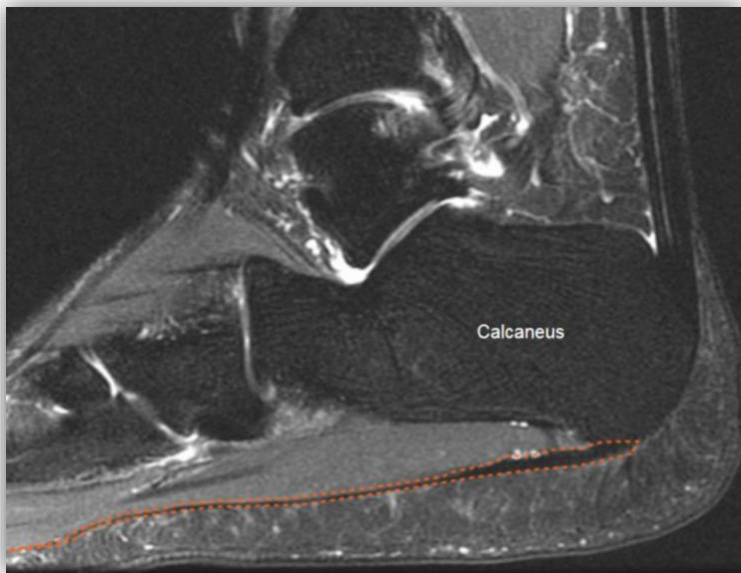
Typical plantar fascia anatomy. Sagittal T2-weighted fat-saturated MR image demonstrates the plantar fascia (orange dashed outline) attaching posteriorly to the medial process of the calcaneal tuberosity. Anteriorly, the fascia blends with the flexor digitorum brevis tendon fibers.
